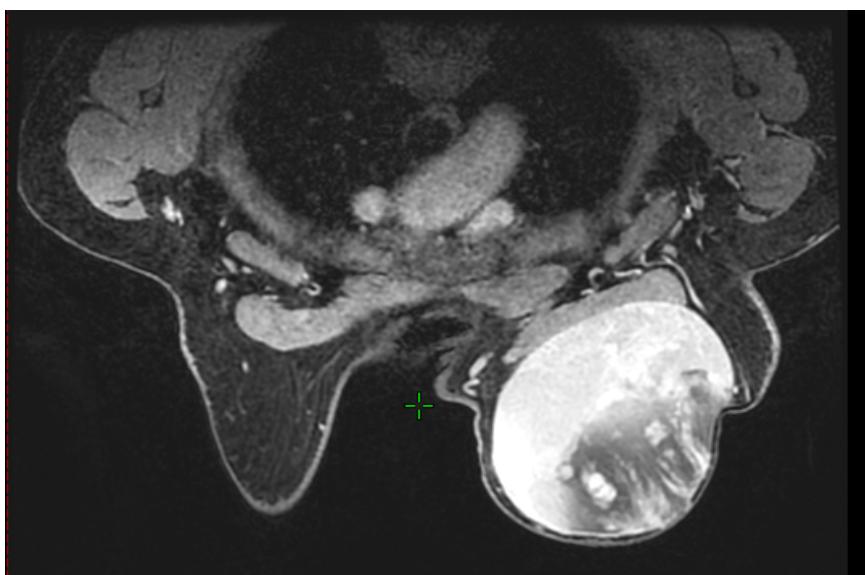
T1-weighted breast MRI with gadolinium contrast showing a large mass in the left breast with heterogeneous enhancement.
